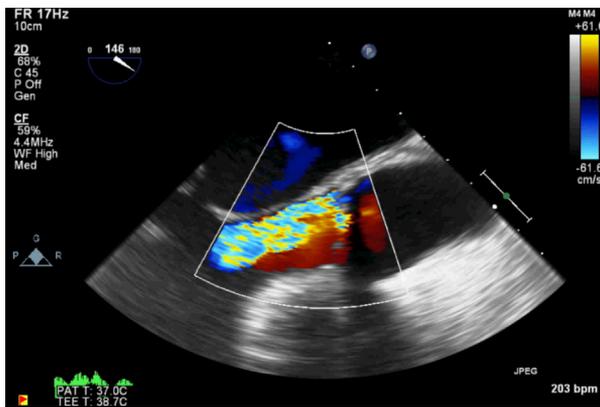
Preprocedure transesophageal echocardiography revealing an eccentric jet of severe aortic insufficiency via color-flow Doppler.
